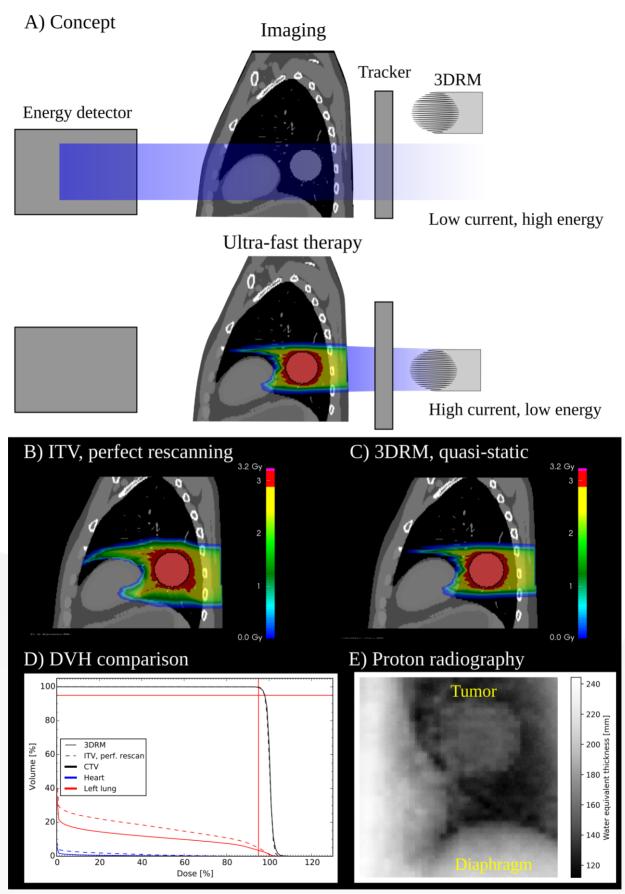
A) Schemtic depiction of the concept. B) Planned dose for an ITV plan, assuming perfect rescanning. C) Dose with a 3DRM, applied quasi static. D) Comparison of DVHs. E) Single-event proton radiograph (5x10⁶ primaries at 230 MeV initial energy) of a 10x10cm² field-of-view including the tumor and diaphragm.
